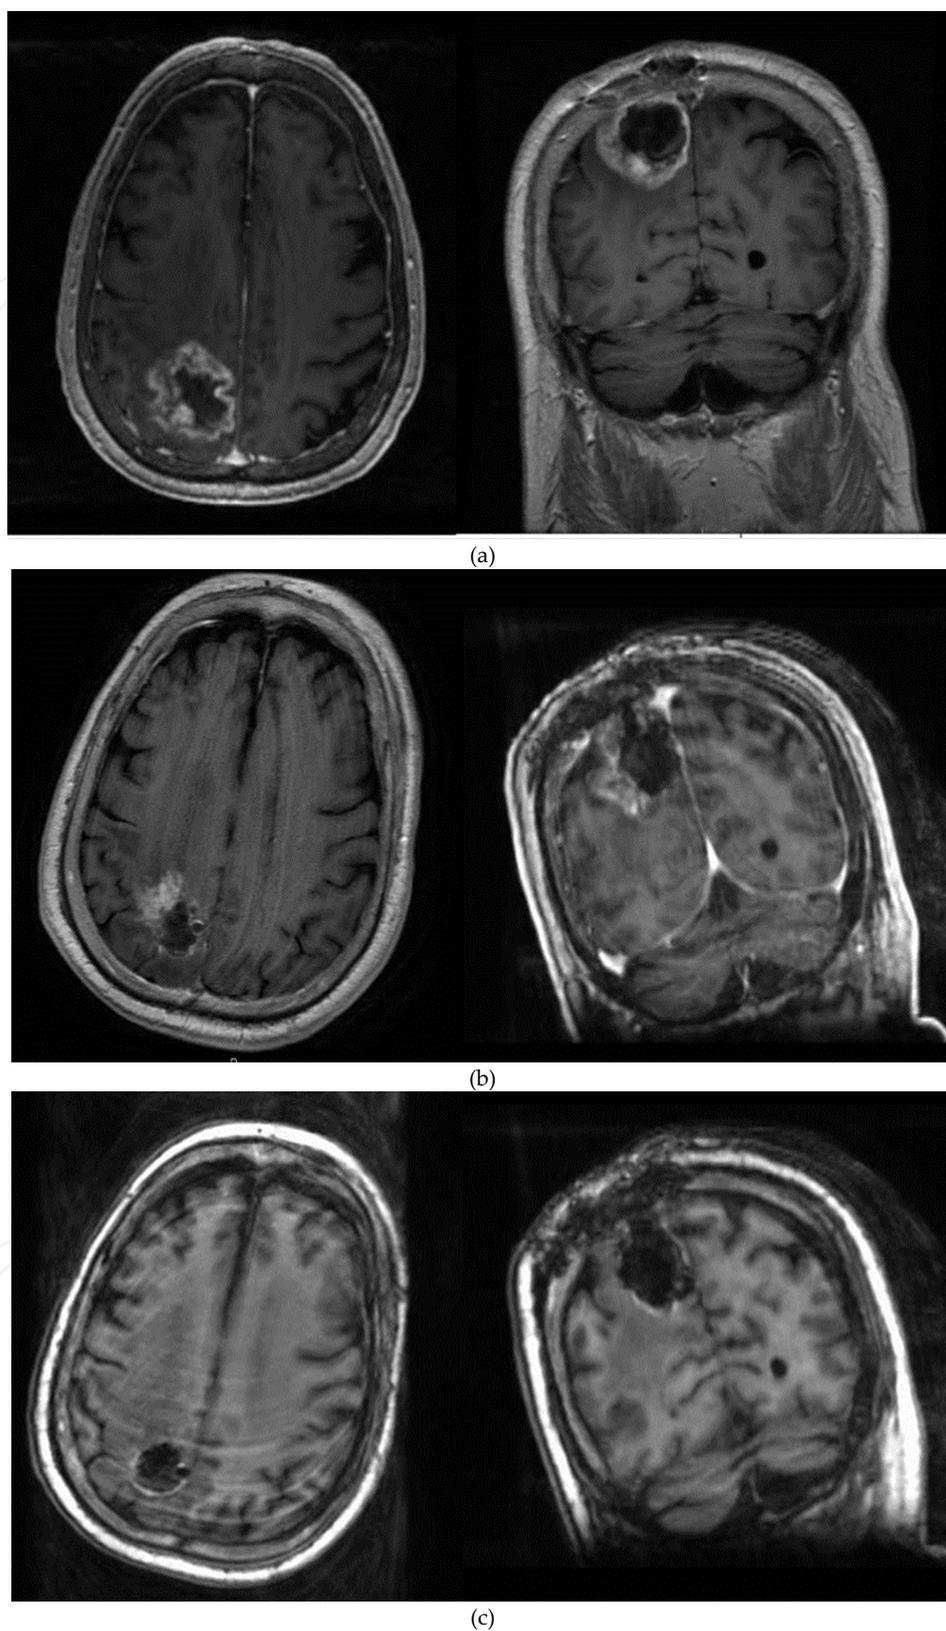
Post contrast axial and coronal T1-weighted images of recurrent GBM, A. Preoperative; B. First intraoperative (showing residual tumor along the lateral wall); C. Second intraoperative MRI scans
